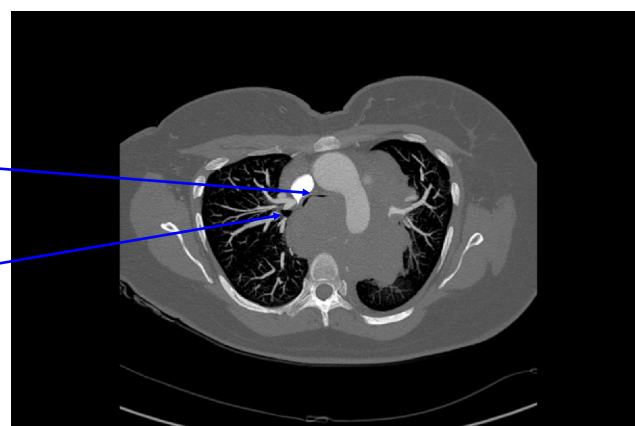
Chest computed tomography scan at level of the mid trachea. The trachea diameter is 3.6 mm
